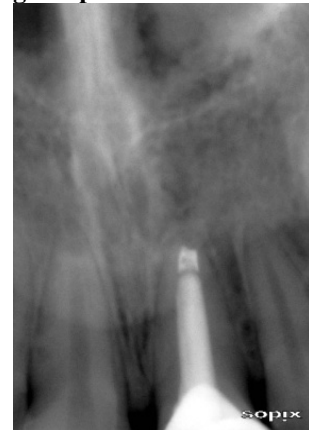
At the end of one year radiograph reveals healthy periapical area with additional root development.
